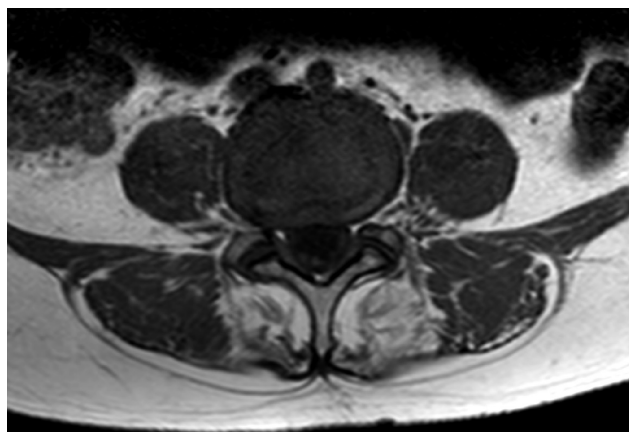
MRI of lumbar spine shows selective fibrofatty degeneration of multifidus part of paravertebral muscles.
